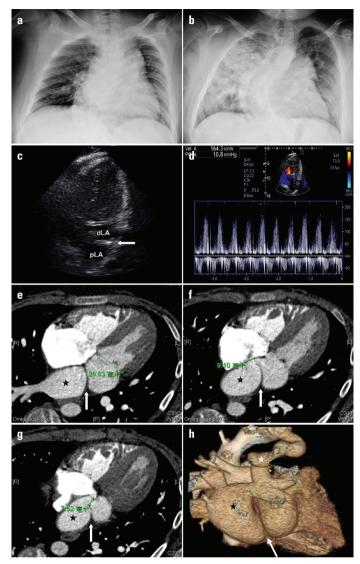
(a) Chest radiogram shows only scoliosis before appendectomy. (b) Chest radiogram shows pulmonary edema two days after laparoscopic appendectomy. (c) Two-dimensional echocardiography shows a membrane (arrow) that separates the left atrium (LA) into a proximal LA chamber (pLA) and a distal LA chamber (dLA). (d) Doppler echocardiography shows a pressure gradient of 10.8 mm Hg across the orifice of the limiting membrane. Chest computed tomography (CT) shows (e) a limiting membrane (white vertical arrow) that separates the left atrium into a proximal chamber (black star) and a distal chamber, and a 26.8-mm intact mitral valve, (f) a 9.1-mm secundum atrial septal defect between the proximal chamber (black star) and the right atrium, and (g) a 7.5-mm orifice in the limiting membrane (white vertical arrow), indicating the presence of Lam type A1 cor triatriatum sinister (CTS). (h) Three-dimensional chest CT, viewing from the posterior aspect, shows a large levoatriocardinal vein (white star) that connects the left upper pulmonary vein and the left innominate vein. This vein was measured approximately 20.0 mm in diameter at its junction with the left upper pulmonary vein and 10.0 mm at its junction with the left innominate vein. Of note is that, there is a deep groove (oblique white arrow) downstream the proximal LA chamber (black star). This external deep groove anatomically corresponds to the internal location of the limiting membrane downstream the proximal LA chamber (black star). This is a living tribute to the embryogenesis of the mal-incorporation theory indicating that CTS occurs due to a failure of incorporation of the common pulmonary vein into the primitive LA during the fifth embryonic week
